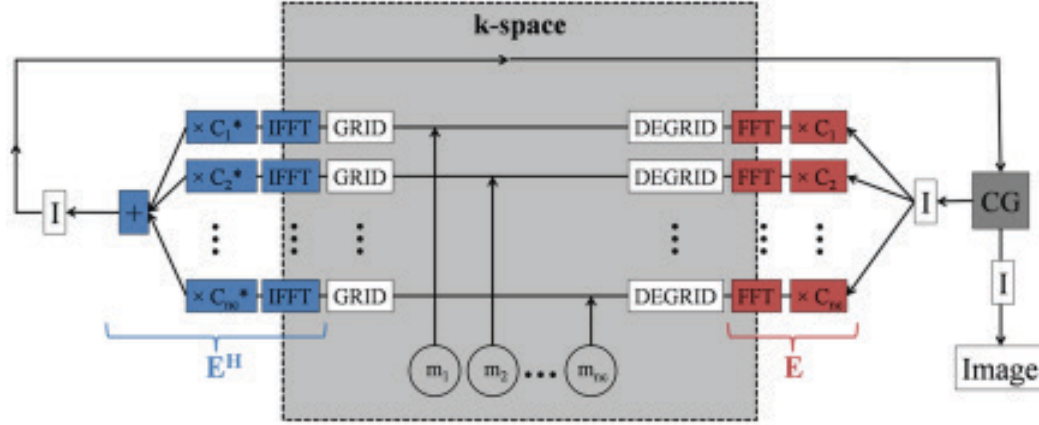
A summary of the CG SENSE algorithm, which reconstructs an image from undersampled non-Cartesian data. Undersampled, multi-channel  $k$ -space data ( $m_1, m_2, \dots, m_{nc}$ ) are acquired and fed into the algorithm. These data are density compensated, gridded, the inverse Fourier transform calculated, and the multi-coil images are multiplied by the conjugate of the coil sensitivities. The multi-coil images are summed and intensity corrected to produce a single image, which is fed into the CG algorithm. The CG algorithm finds a new estimate for the reconstructed image. If the reconstruction has not converged, intensity correction is applied, the image is multiplied by the coil sensitivities, the Fourier transform is calculated, the data are degridded, the original data replaced, and the next iteration begins. This process continues until the reconstruction converges and a stopping criterion has been met. Once the stopping criteria are met, intensity correction is applied, and the result is an unaliased image. [Color figure can be viewed in the online issue, which is available at [wileyonlinelibrary.com](http://wileyonlinelibrary.com).] Reprinted, with permission, from Wright et al, *Non-Cartesian Parallel Imaging Reconstruction*, Journal of Magnetic Resonance Imaging, Vol. 40, Issue 5, pg. 1022-40 © 2014 Wiley Periodicals, Inc. [98]
